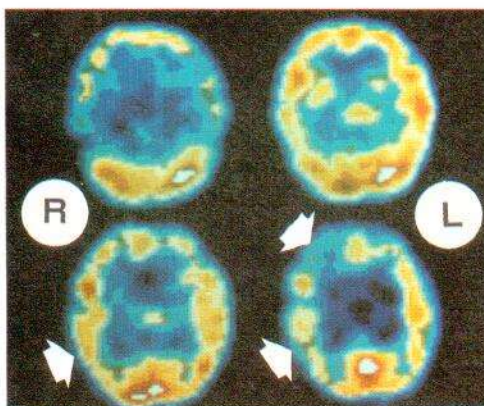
13-year-old mentally retarded girl with nondefined progressive encephalopathy. SPECT showed hypoperfusion in right hemisphere.
